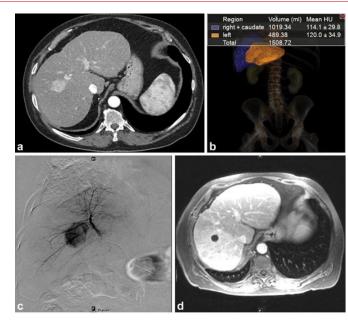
(a) Baseline triphasic CT scan of a 66-year-old patient with hepatitis C cirrhosis and unresectable HCC in the right lobe. (b) Volumetric assessment shows a baseline FLR of 32%. (c) The patient underwent radiation lobectomy in the right lobe. (d) MRI follow-up at 2 months post-Y90 demonstrates complete tumor response by mRECIST criteria.
